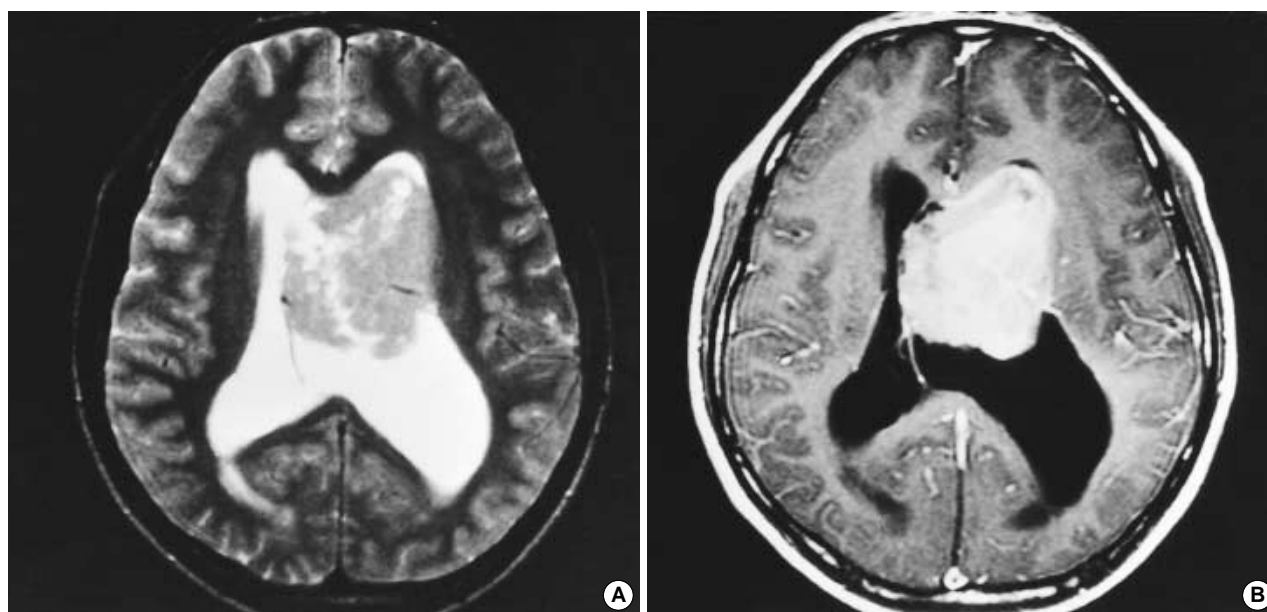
A T2-weighted (A) and gadolinium-enhanced T1-weighted (B) MR images in the patient of case 14 demonstrate a 5 cm-sized intra-ventricular mass located in the left lateral ventricle. Asymmetrical enlargement of the lateral ventricle in the left side is found, where the main portion of the tumor is located. The septum pellucidum is well preserved but displaced to the contralateral ventricle delineating the medial contour of the tumor.
